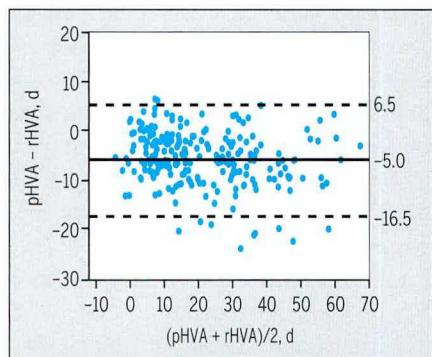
Bland-Altman plot of the difference between pHVA and rHVA. The solid line indicates the mean difference, and the dotted lines indicate the 95% limits of agreement. Abbreviations: pHVA, photographic hallux valgus angle; rHVA, radiographic hallux valgus angle.
